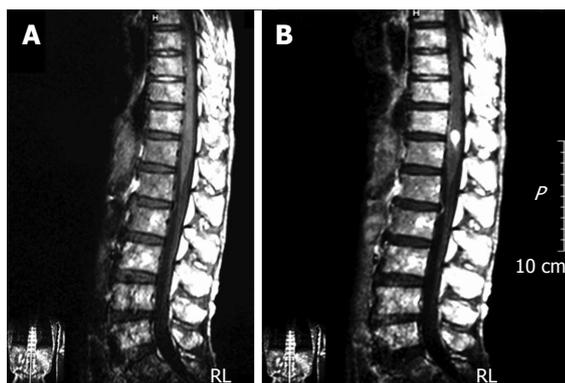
The thoracolumbar T1-weighted magnetic resonance imaging. Though unenhanced magnetic resonance imaging (MRI) revealed no abnormal finding (A), gadolinium diethylenetriaminepentaacetic acid enhanced MRI indicated a spot on the spinal cord at the Th12 level (B).
